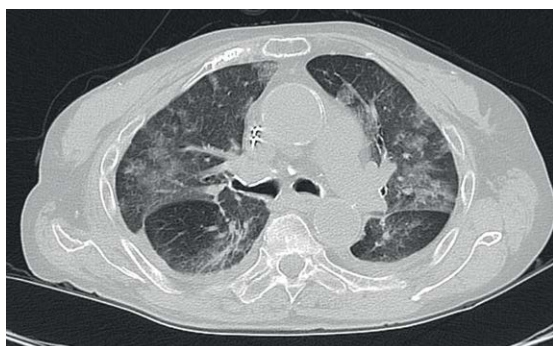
CT scan of the chest revealing peripherally located ground-glass opacities and bilateral patchy consolidations.
